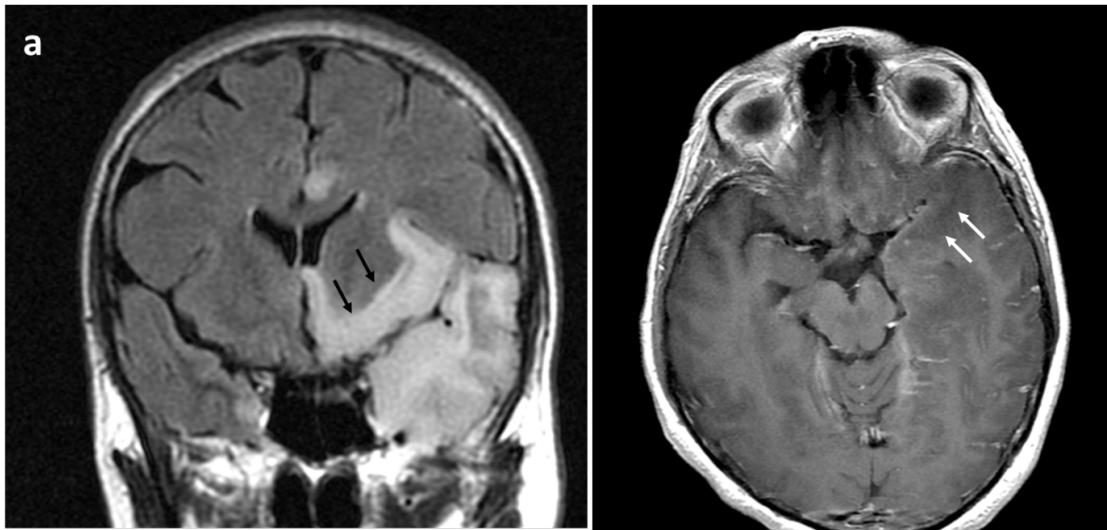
a. A 58-year-old male with infectious encephalitis, CSF grew Strep pneumoniae. The MRI image on the right of Fig 1a shows Coronal FLAIR images which demonstrates an asymmetrical hyperintense lesion in the left inferior frontal (black arrow), right cingulate and right temporal lobe. The MRI image on the left of Figure 1a shows axial T1W post gadolinium images which demonstrates leptomeningeal enhancement (white arrow).
